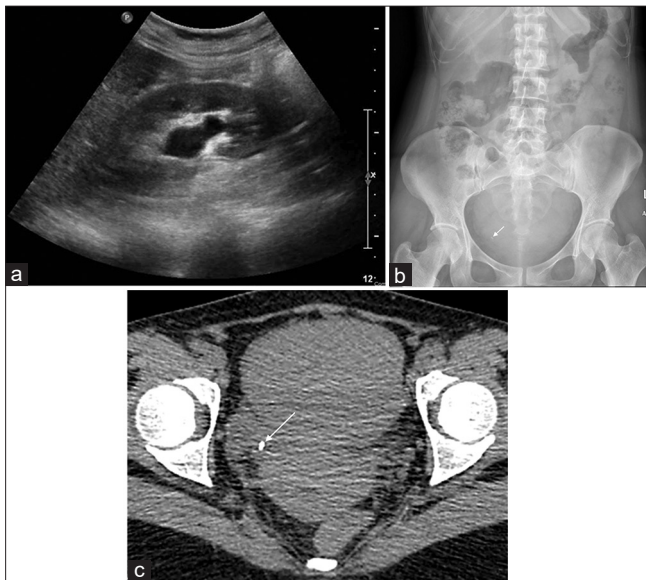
Obstructive right ureteric stone. Ultrasound (a) of a 43-year-old woman reveals mild hydronephrosis while radiography (b) shows distal ureteric stone (arrow). Computed tomography (c) confirms the diagnosis (arrow)
